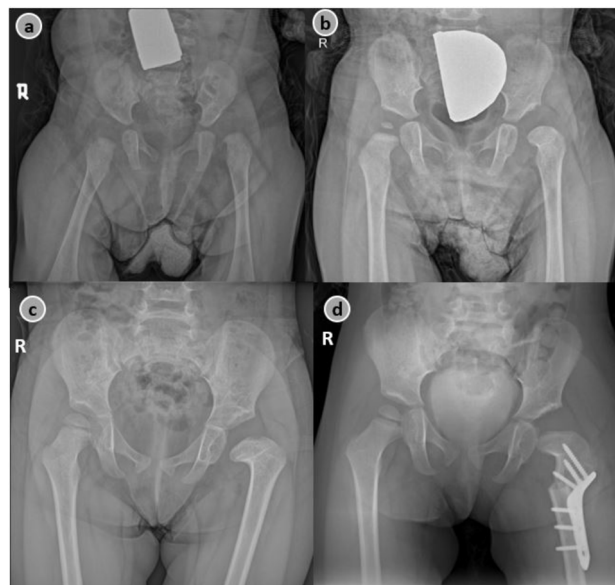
Radiographic views of a hip that developed AVN after MOR and is undergoing valgization osteotomy. Anteroposterior radiographs of a 7-month-old female with left DDH (a), AVN development in the left hip in the first year postoperatively (b), 2 years following MOR (c), and 4 years after MOR, valgisation osteotomy was performed (d) AVN: Avascular necrosis, DDH: Developmental dysplasia of the hip
